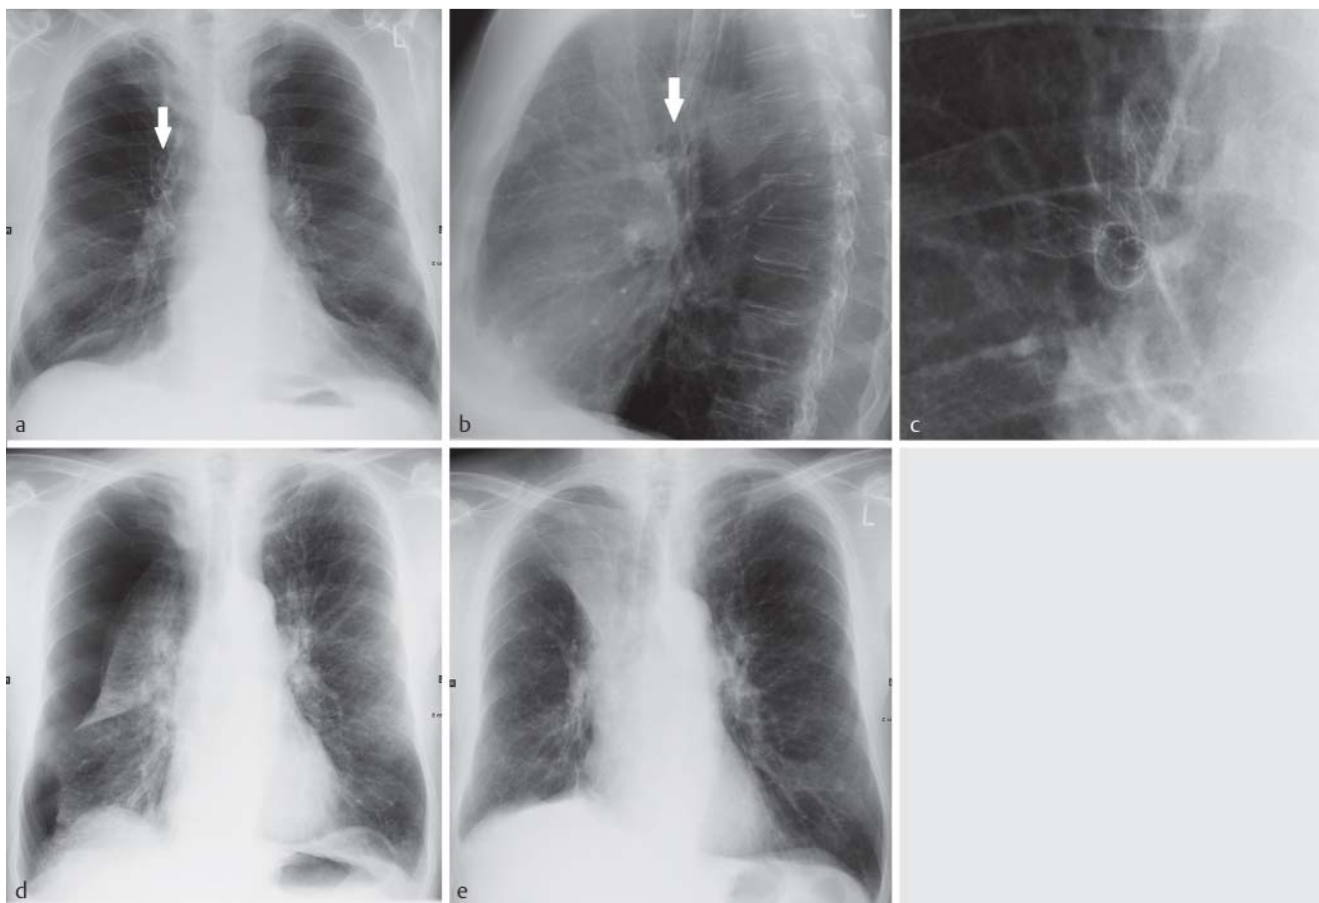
shows radiographs of endobronchial valves. a–c shows a valve (arrow) lying in the right superior lobe of a 63-year old patient one day following implantation. (a p. a., b side projection, c enlarged view of p. a.). d, e show p. a. images from a 70-year old patient taken day 1 d and day 8 e following valve implantation in the right superior lobe. The centrally lying
